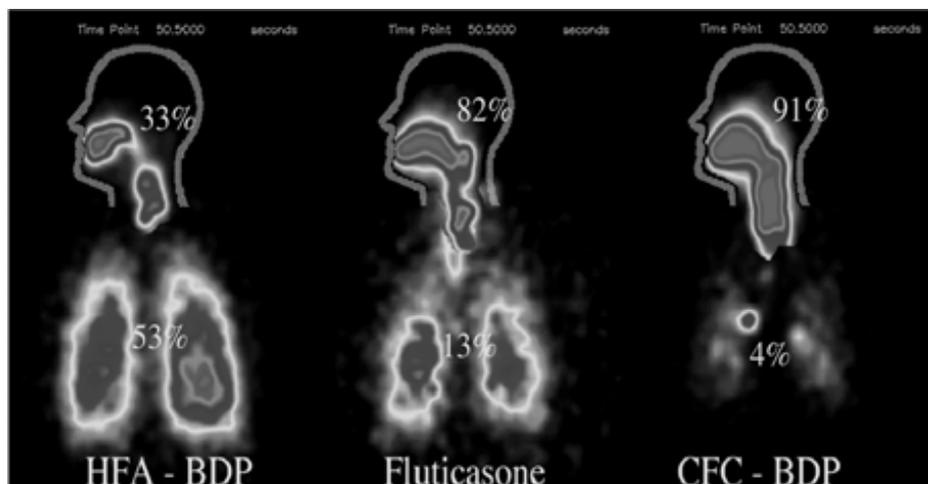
Comparison of gamma scintigraphic scans of HFA-BDP, CFC-BDP and fluticasone.
